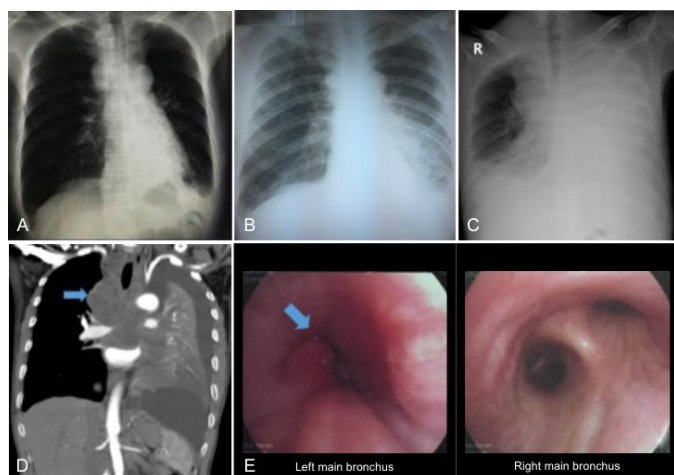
Serial photo showing: (A) Initial CXR, which represents the diagnosis of pulmonary tuberculosis. (B) Two months of follow-up CXR after initiation of anti-tuberculosis treatment showed no improvement. (C) CXR by the time at the emergency unit, five months after the first CXR. (D) Chest CT scan showed a central pulmonary mass (pointed by the blue arrow) obliterating the right thoracic space, resulting in SVCS and obstructing the left main bronchus and pleural and pericardial effusion. (E) The bronchoscopy imaging showed total left main bronchus obstructed by infiltrative tumor mass (pointed by the blue arrow).
